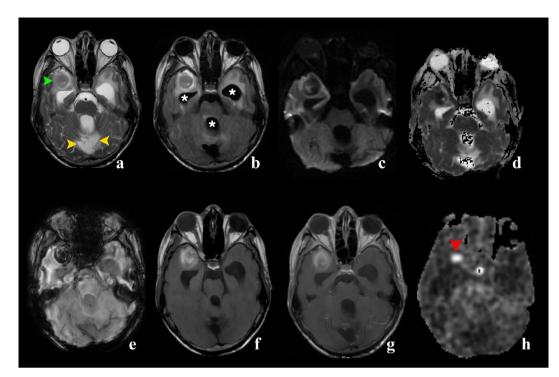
Patient B., 12 y.o., with central nervous system germinoma after chemotherapy and radiotherapy. T2 and T2 FLAIR axial weighted images (a and b) show the black zone of postoperative encephalomalacia along the pine region approach (yellow arrows). IV-th ventricle and the temporal horns of the lateral ventricles are dilated with transependymal swelling of the periventricular substance (stars in b). In the real pole of the right temporal lobe, an "intra-axial" mass is detected, isointense to the gray matter in T2 and T2 FLAIR (a, green pointer). The signal characteristics correspond to blood (low signal in SWI, e) in the early subacute phase (irregularly high signal in T1, f). Diffusion are limited according to the ADC map (d). The lesion does not demonstrate contrast enhancement against the background of hemorrhage: the pole of the right temporal lobe on pre- and post-contrast T1 images (f and g) does not differ in signal intensity. Raw ASL perfusion data (h) indicate the presence of an area of hyperperfusion (increased cerebral blood flow velocity) in the lesion as a high signal focus at the pole of the right temporal lobe (red pointer).
